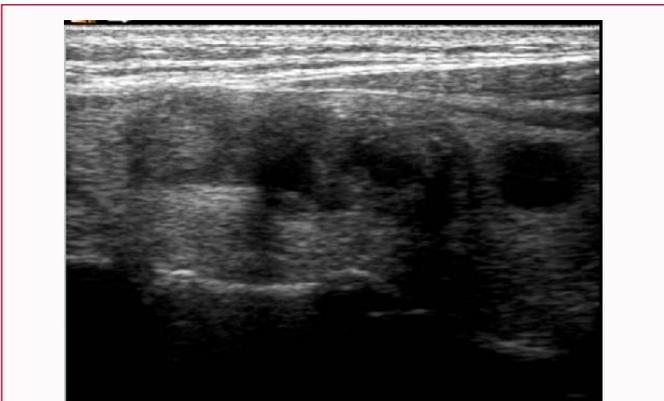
Color Doppler ultrasound of thyroid and cervical lymph nodes revealed: (1) Cystic and solid nodules in the left lobe of thyroid. (2) Hypoechoic nodules in the right lobe of the thyroid.
